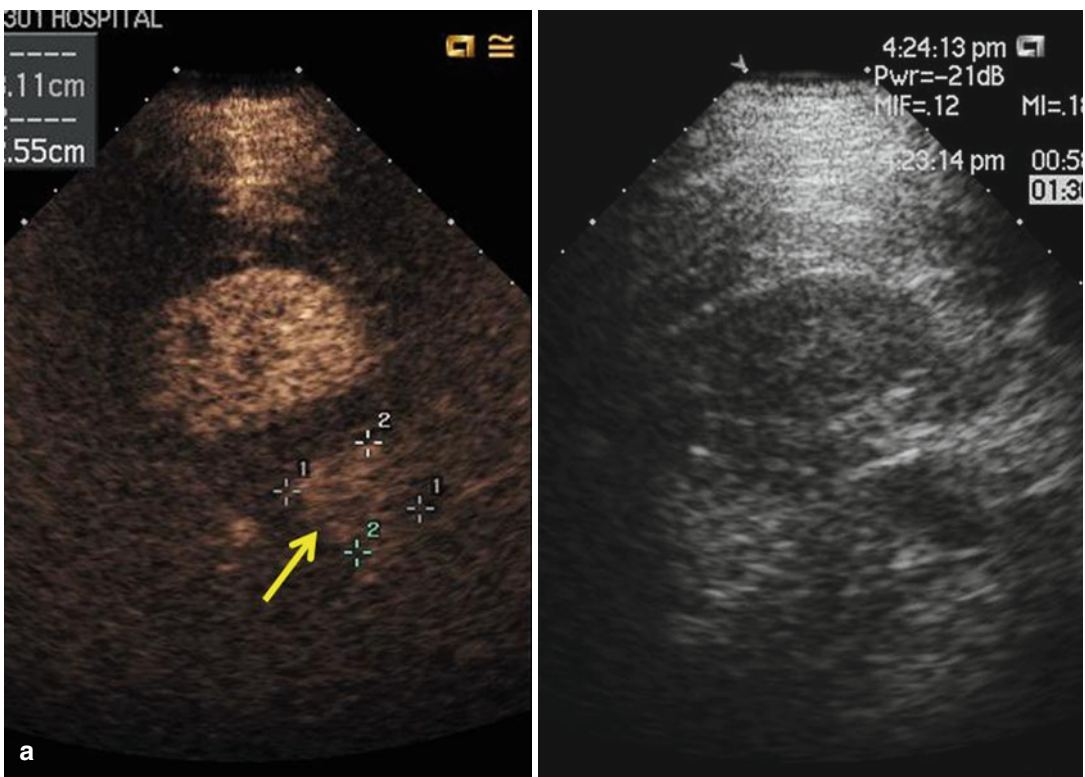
MWA in a 64-year-old man with left adrenal metastasis (3.1×2.6 cm), who had hepatocellular carcinoma treated with transarterial chemoembolization 1 year ago. (a) Contrast-enhanced ultrasound scan obtained before ablation shows tumor enhancement (arrow) at arterial phase. (b) T2WI on MRI scan obtained before ablation shows a well-demarcated tumor (arrow) on the left
